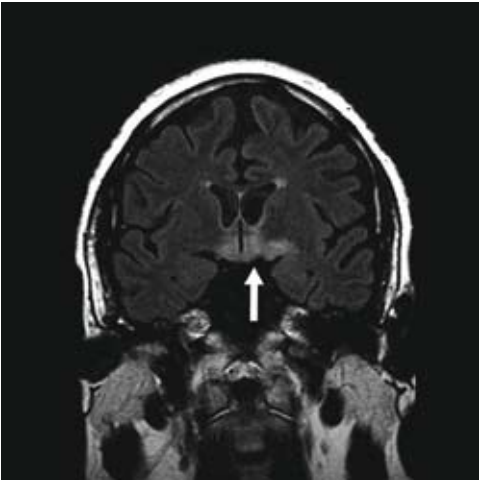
Brain MRI: sagittal flair.
